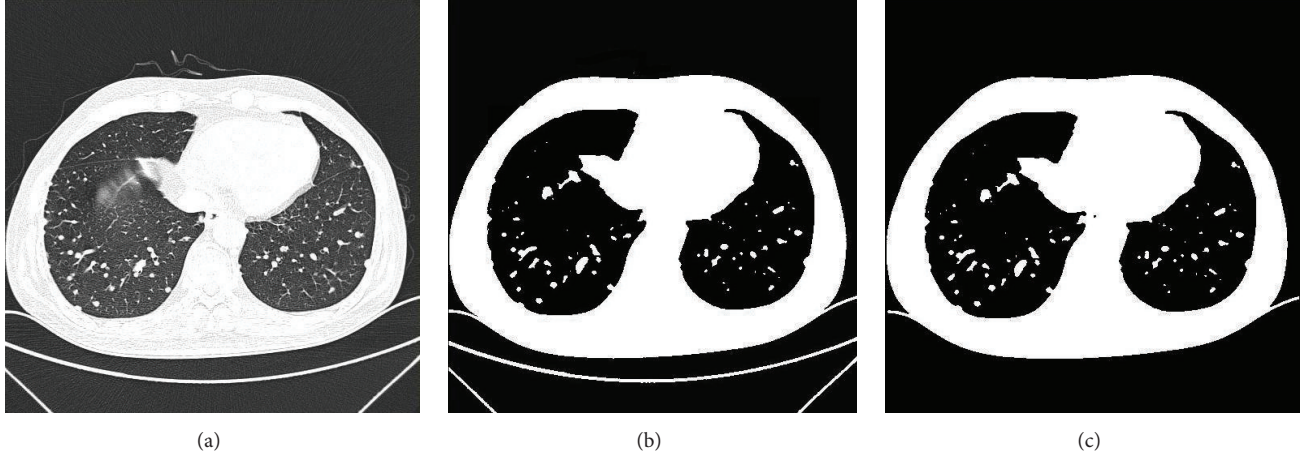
Thorax extraction by region growing. (a) Input CT image. (b) Binarized CT image. (c) Extracted thorax using region growing.
